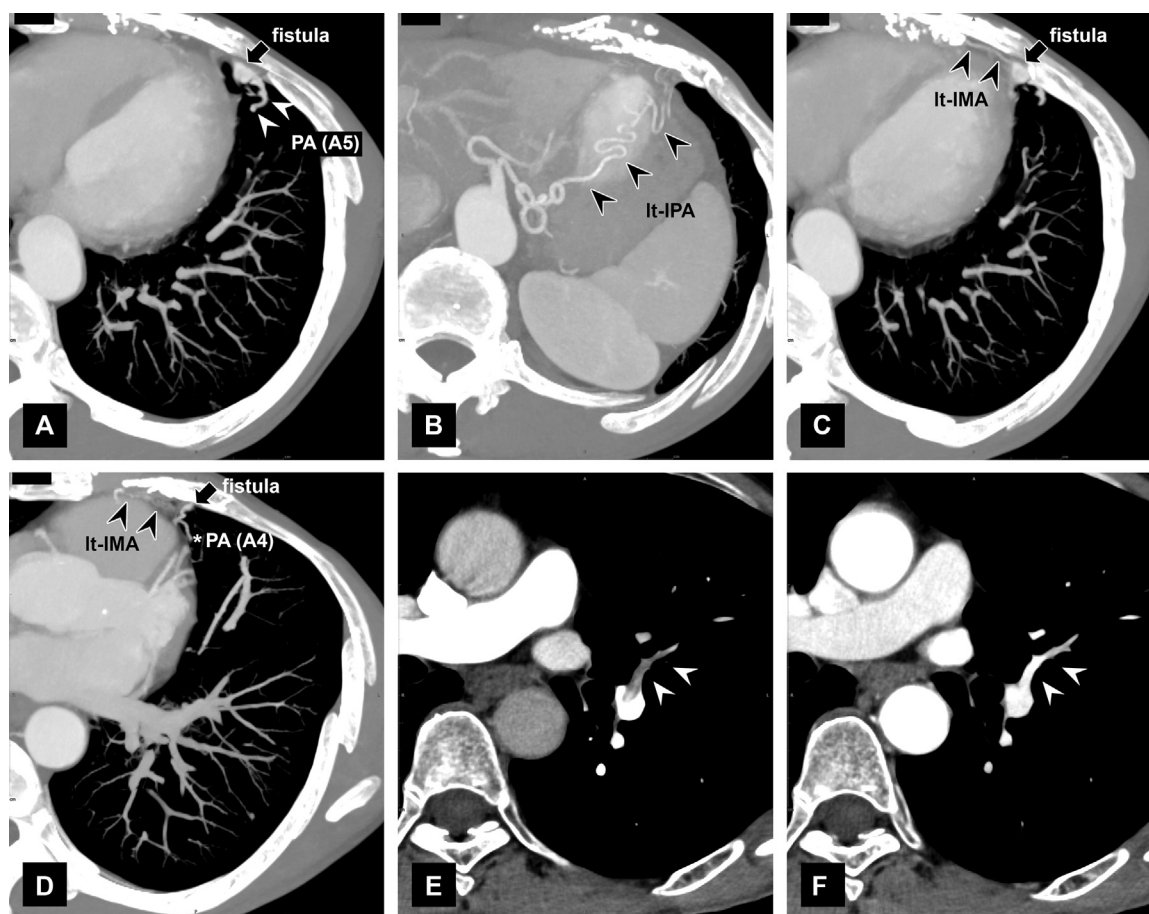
Contrast-enhanced computed tomography (CT) findings. Contrast-enhanced CT maximum intensity projection highlights a dilated and tortuous pulmonary artery (PA) A5 segment (arrowheads) forming a fistula (arrow) with a bulbous, aneurysmal dilation in the lingula of the left lung (A). The ascending left inferior phrenic artery (lt-IPA, arrowheads) extends and meanders toward the fistula (B). The left internal mammary artery (lt-IMA, arrowheads) runs near the fistula (arrow) and is suspected to be continuous with it (C). The lingula of the left lung shows another small fistula (arrow) contiguous with the PA A4 segment (asterisk), with the left internal mammary artery (lt-IMA, arrowheads) running nearby (D). In the pulmonary artery phase, contrast loss is observed on the central side of the PA A5 segment (E), while the late phase shows uniform contrast enhancement (F).
